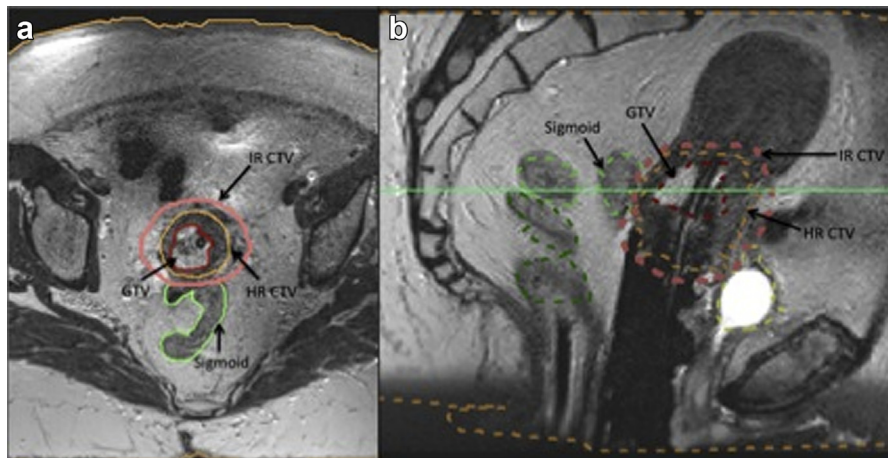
Contours at Fraction 1 for the HR-CTV, GTV, and OAR according to the GEC-ESTRO guidelines using MRI-based adaptive brachytherapy using 3-T MRI. HR-CTV = high-risk clinical target volume; IR-CTV = intermediate risk volume; GTV = gross tumor volume; OAR = organs at risk.
